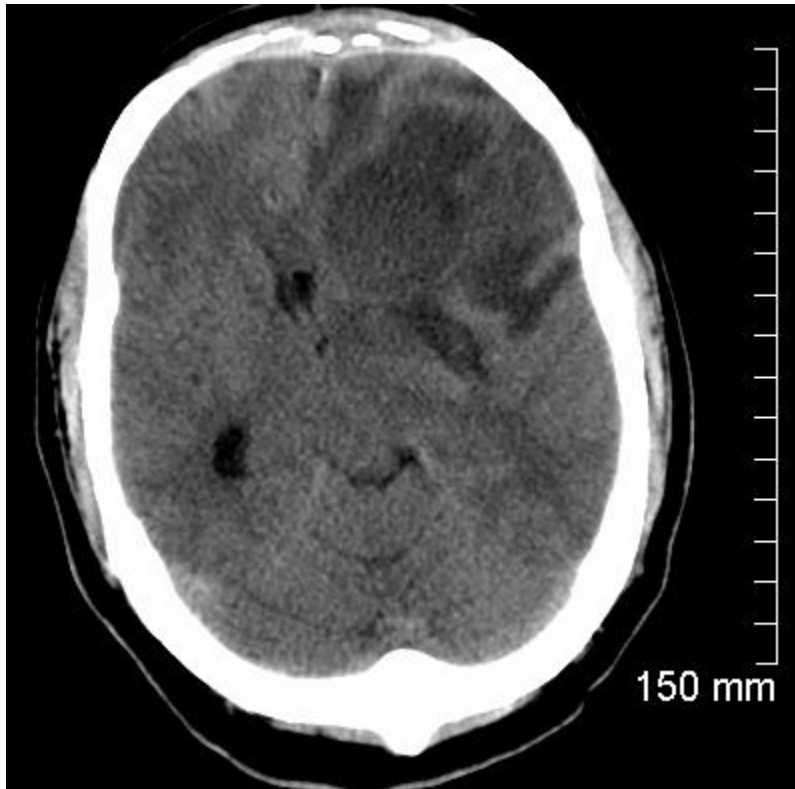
CT image with no contrast shows significant vasogenic edema involving the left frontal lobe suggesting either an underlying mass or abscess. There is significant mass effect with left-to-right midline shift measuring 1.6 cm in length. There is subfalcine herniation and partial obliteration of the suprasellar cistern. Dilatation of the right lateral ventricle suggests obstruction at the level of the foramen of Monro.
